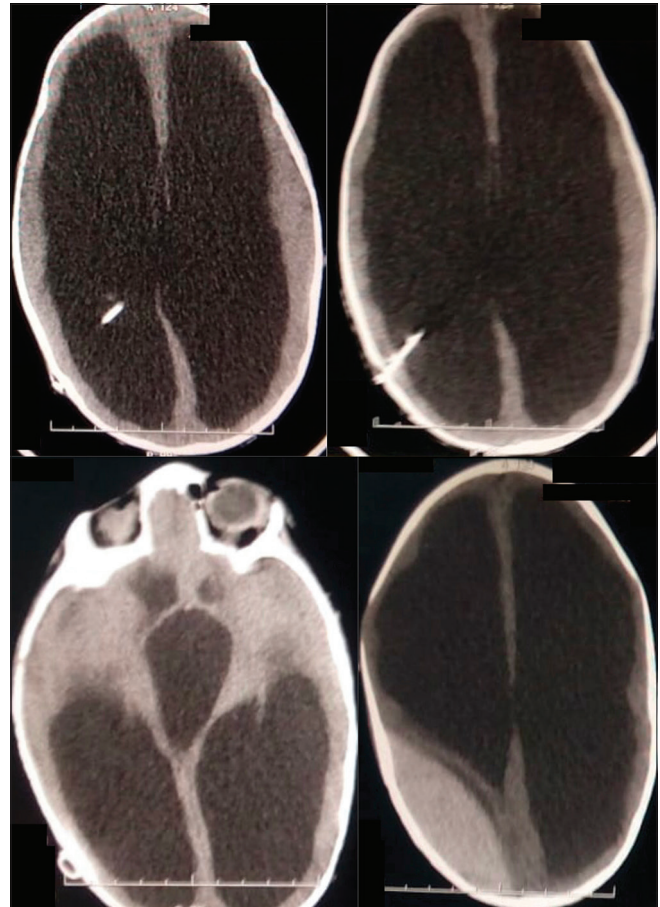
Computed tomography head showing a right parietal large epidural hematoma away from the shunt track and hydrocephalus.
